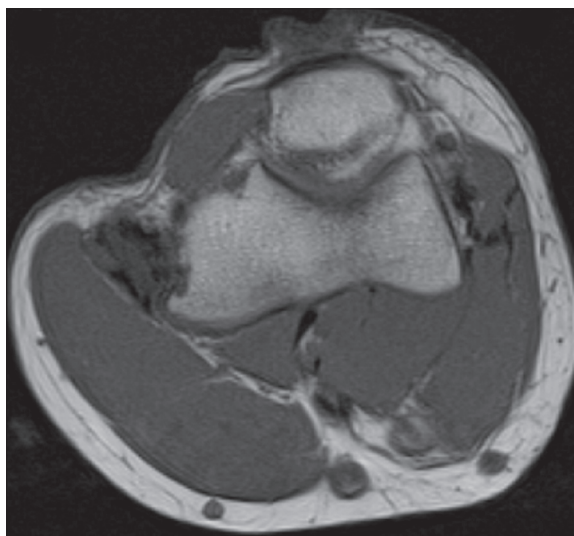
MR of the cubital joint; FSE sequence, T1-weighted image in axial plane in the same patient. Thickened enthesis with heterogeneous signal. Features of osseous destruction.
